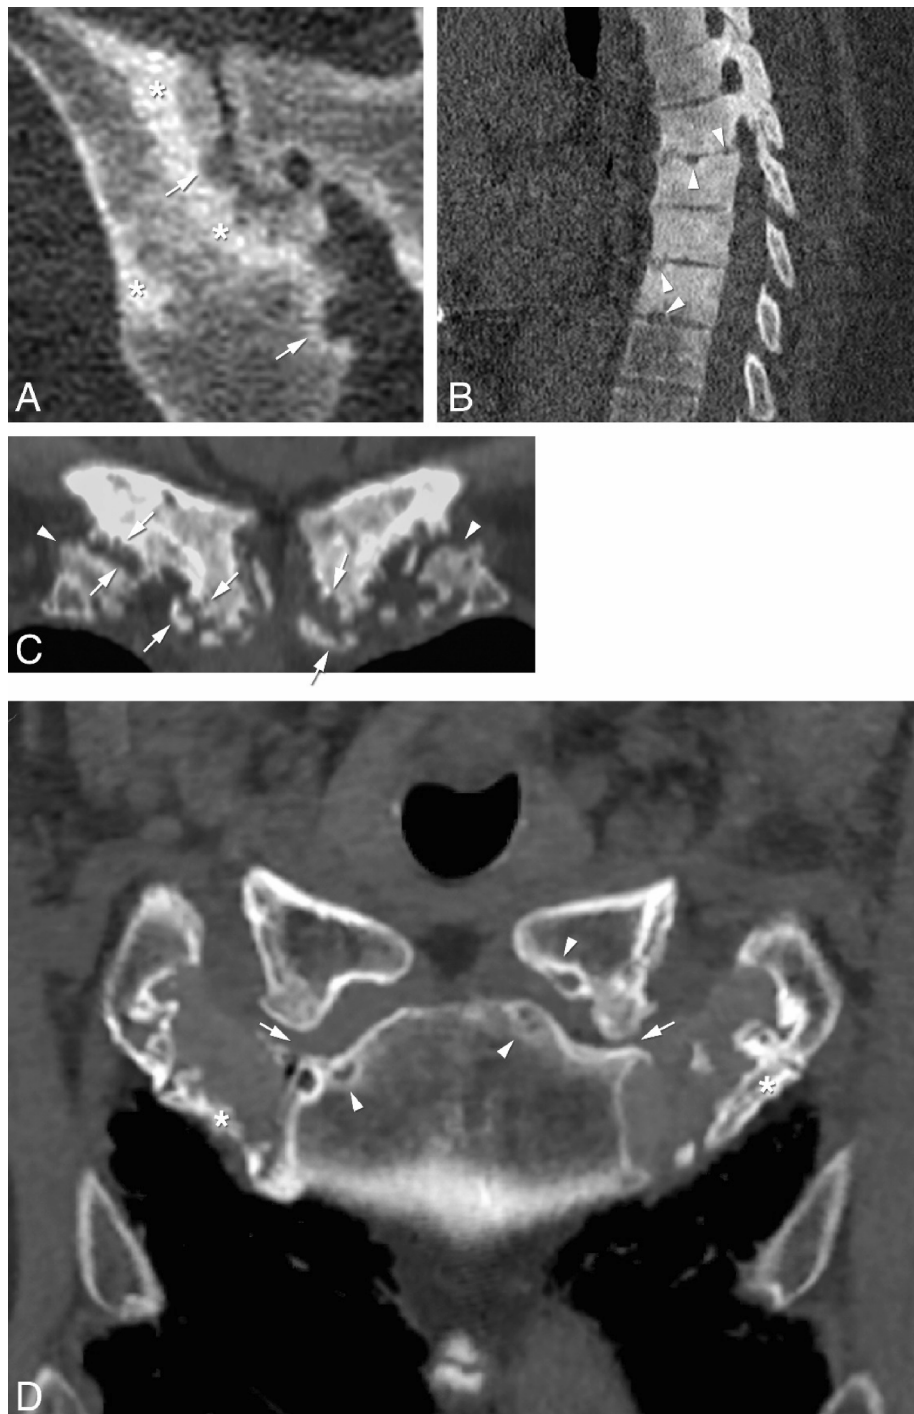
Examples of common locations of bone erosions in adult CNO and pitfalls. A: (axial CT view) erosions in the right SI joint (arrows), with associated sclerosis of the iliac bone (asterisks). B: (sagittal CT view) erosions in the thoracic spine (arrowheads), with diffuse sclerosis. C: (coronal CT view) “kissing” erosions in the medial ends of both clavicles and sternum adjacent to the sternoclavicular (SC) joint (arrows), associated with mild hyperostosis, sclerosis and calcifications of the costoclavicular ligaments (arrowheads). D:(coronal CT view) a case of osteoarthritis of the anterior chest wall (pitfall) shows subchondral sclerosis and osteophyte formation at the level of the proximal ends of the clavicles and manubrium sterni (arrows), with subchondral bone cysts surrounded by sclerotic margins in the left clavicle and in the manubrium sterni on both sides (arrowheads); note that the sternoclavicular joint space on the left side is narrowed and asymmetric, with subtle vacuum phenomena. Additionally, hypertrophic ossifications are present at the first sternocostal (SCo) junctions bilaterally (asterisks), a common pitfall.
